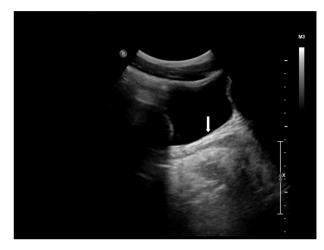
Absence of hematocolpos demonstrated by collapsed vaginal cavity (white arrow) on ultrasound.
